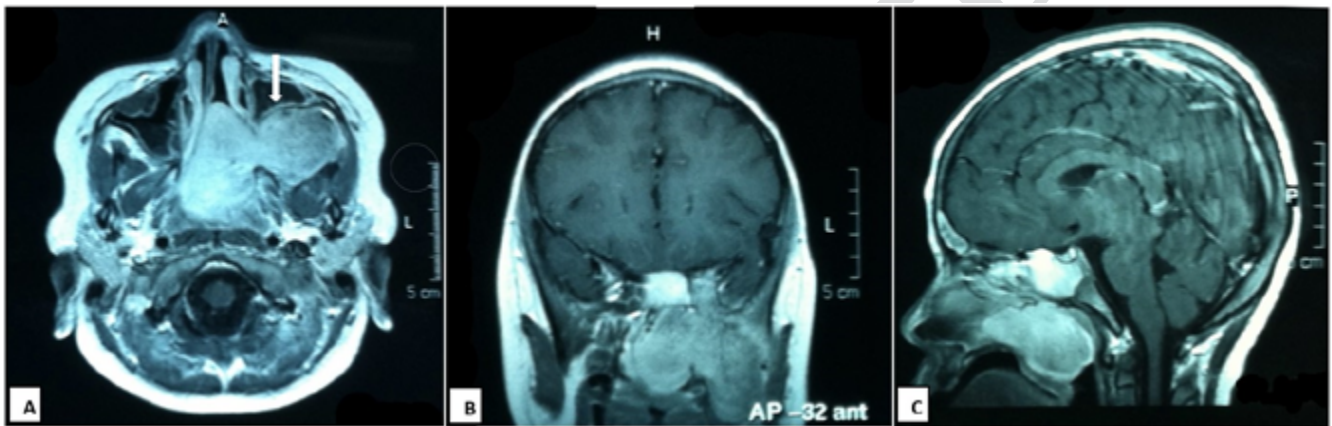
T1 weighted- postcontrast MRI in (A) axial, (B) coronal and (C) sagittal view demonstrate a left sided enhancing nasopharyngeal mass extending to left infratemporal fossa, erosion of basisphenoid involving left cavernous sinus and anterior bowing of the posterior wall of the left maxillary sinus – Holmann Miller sign (A, white arrow).
